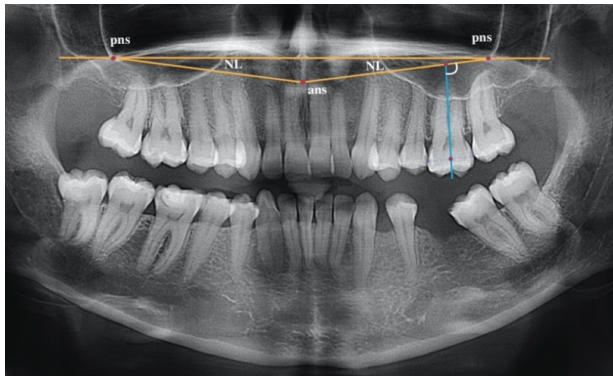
Panoramic radiograph before orthodontic treatment. Inclination of the tooth 2.6 in relation to the maxillary plane (NL)
